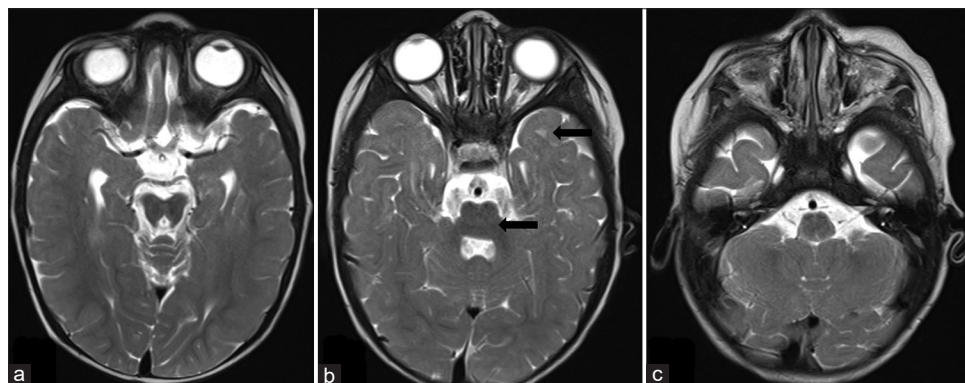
(a–c) MRI brain T2W axial images showing hypoplastic middle cerebellar peduncle with globular dysmorphic pons. Subcortical white matter signal changes in the cerebral hemisphere. MRI = magnetic resonance imaging, T2W = T2 weighted
